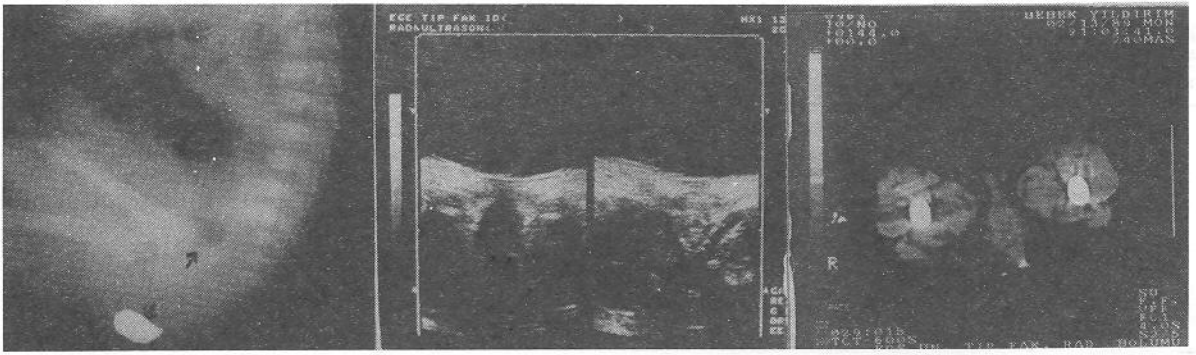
Invertography (left) and Ultrasonography (middle) showing high anomaly, while CT (right) showing how anomaly in Case 4.
